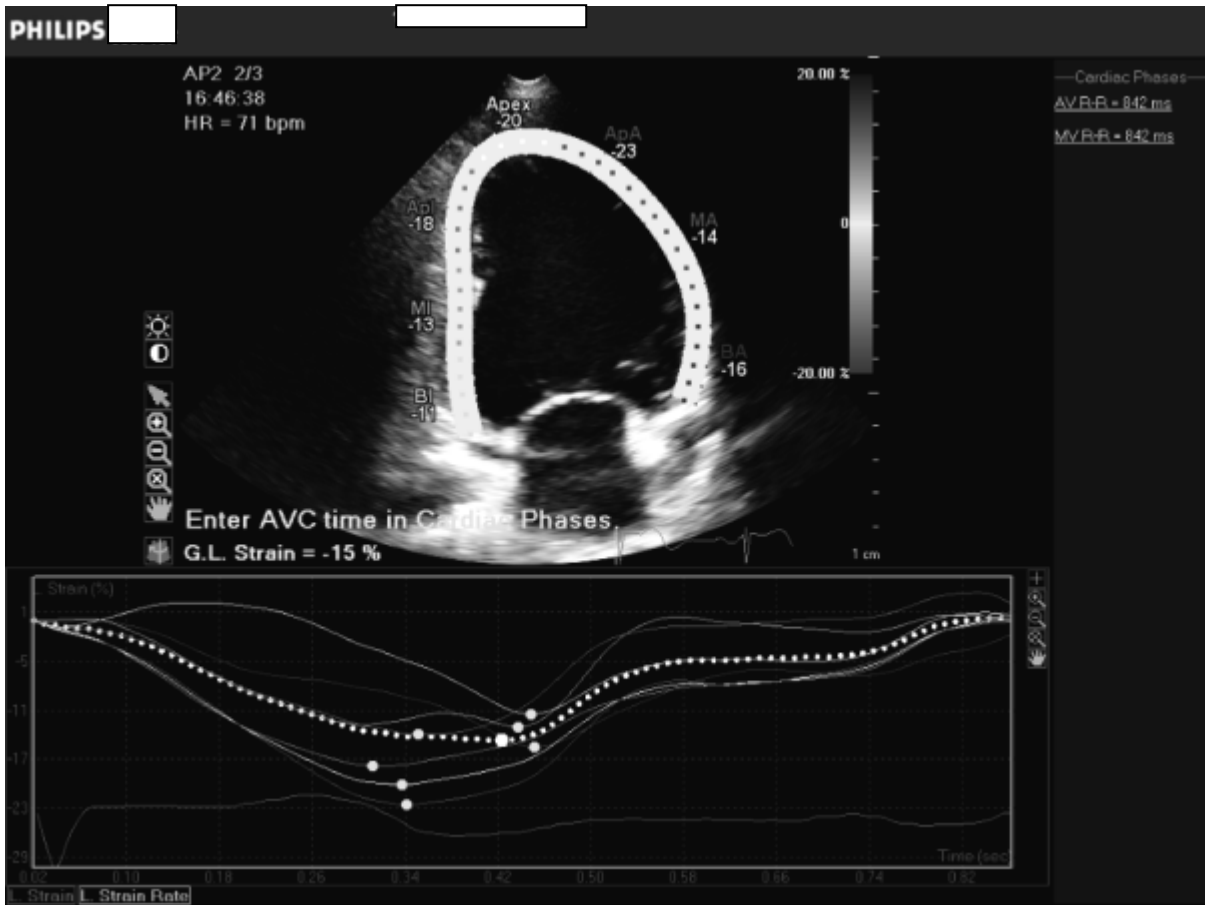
Apical two chamber view for global longitudinal strain
